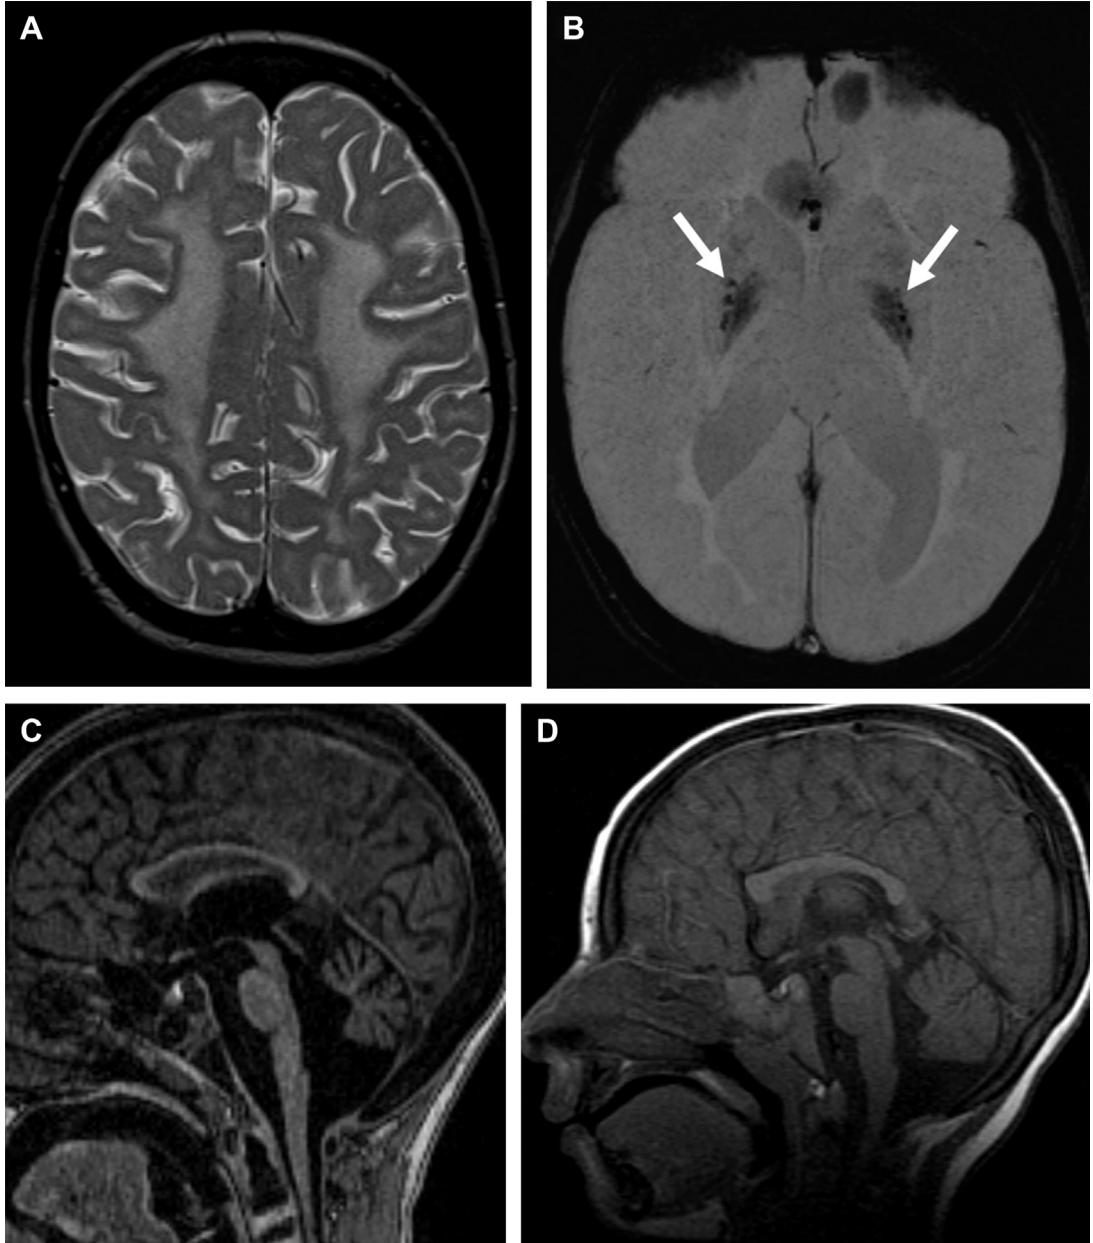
9-year-old girl with Cockayne syndrome. (A) Axial T2-weighted image shows confluent abnormal hyperintense signal in the supratentorial white matter. (B) Axial SWI image shows hypointense signal in bilateral globi pallidi (arrows) consistent with calcifications. (C) and (D) Sagittal T1-weighted images at 9-years and 2-years of age, respectively, showing progressive cerebellar atrophy. (From Wagner MW, Poretti A, Wang T, et al. Susceptibility-weighted imaging for calcification in Cockayne syndrome. *J Pediatr* 2014;165(2):416; with permission.)
